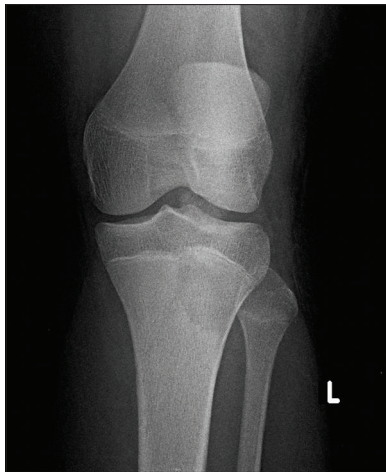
Preoperative radiograph anteroposterior view
